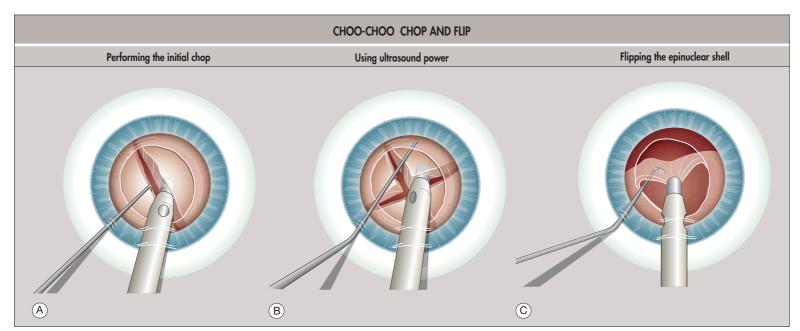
The surgeon performs the initial chop of the nucleus by deeply embedding the phaco needle in the center of the nucleus using ultrasound power, and then maintaining a hold on the nucleus with high vacuum in foot pedal position 2 without ultrasound as the horizontal chopper is brought from the golden ring to the side of the phaco needle to score the nucleus. The surgeon then completes the chop by separating the instruments with a slight upward movement of the phaco tip and a slight downward movement of the chopper (A). Each quadrant of nuclear material is in turn impaled, chopped, mobilized, and consumed with high vacuum and low amounts of ultrasound power (B). Finally, the epinuclear shell is flipped with a helpful push from the chopper (C).
